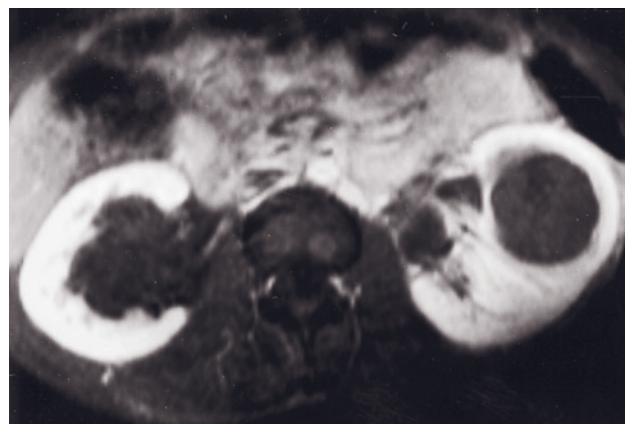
Multiple renal abscesses. T1-weighted 90-s postgadolinium SGE image (*a*) demonstrates multiple signal-void abscesses in the right kidney. T1-weighted fat-suppressed gadolinium-enhanced SE images (*b, c*) in a second patient with HIV infection and elevated serum creatinine. Bilateral renal abscesses with substantial renal enlargement are noted on T1-weighted image (*b*). Ultrasound and noncontrast CT imaging demonstrated renal enlargement with no definition of abscesses. A repeat MRI study
